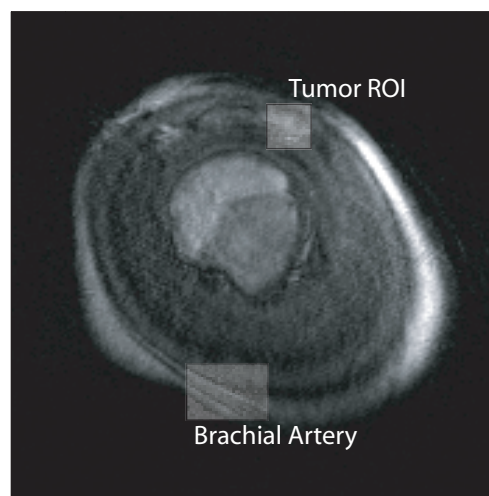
A postcontrast slice frame of this patients DCE-MRI data is included for reference. The brachial artery, from which the measured AIF was obtained, and the tumor ROI are highlighted.
